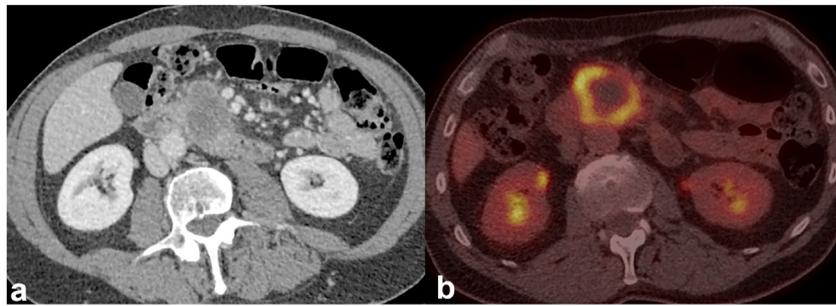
A 64-year-old male with stage 4 PDAC of the pancreatic head (42 mm) and an overall survival of 4 months. The tumor was hypoattenuating on CECT (a) and showed ring-shaped high [^{18}F]FDG-uptake on PETCT (b)
